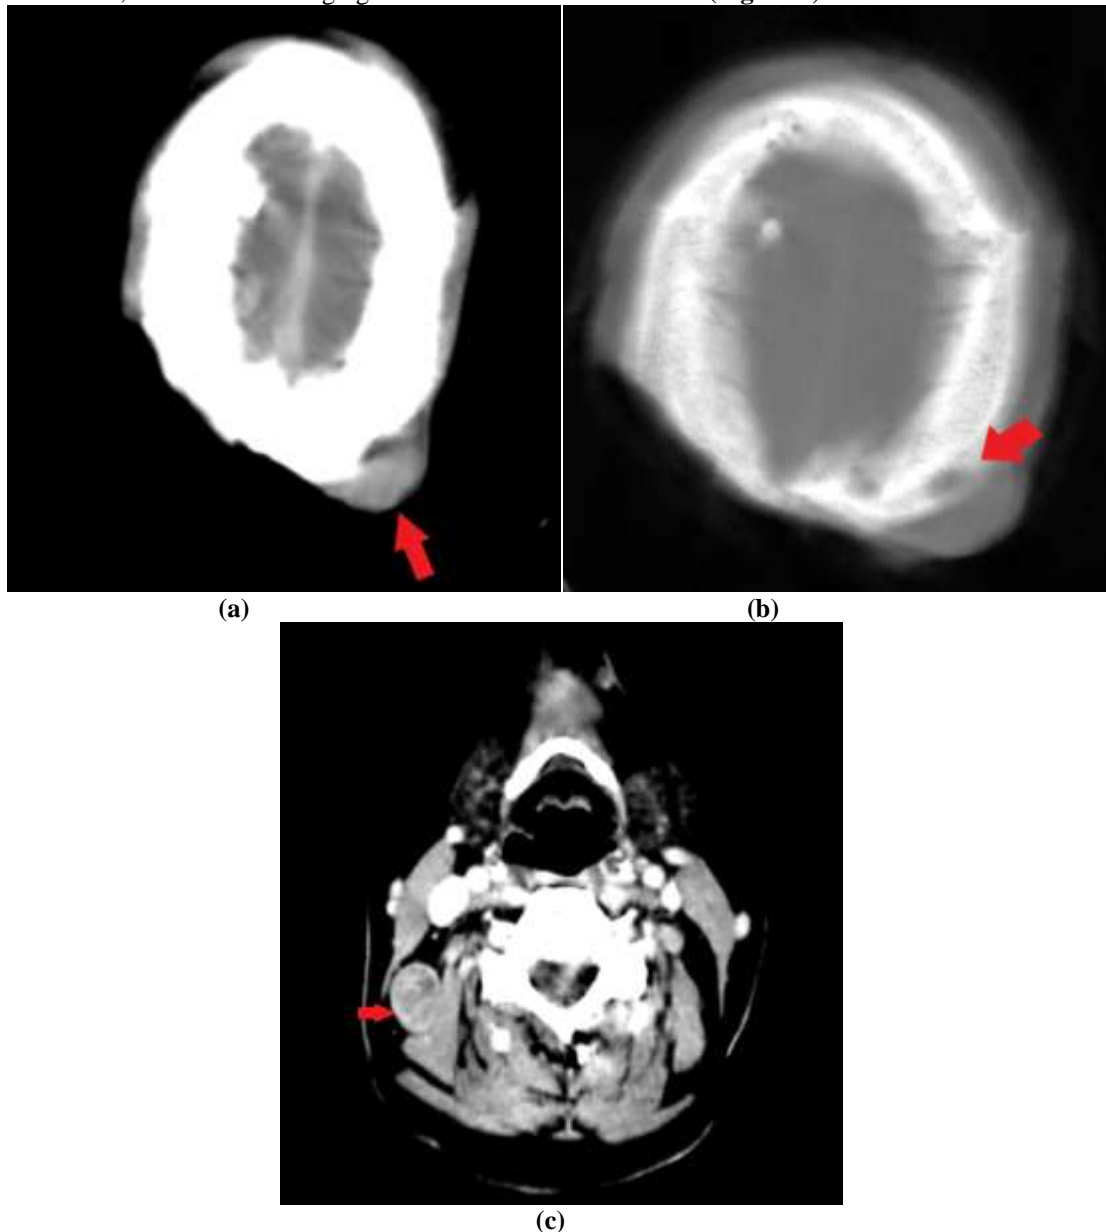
Computed Tomography (CT) scan showing microcystic adnexal carcinoma lesion of the left parietal scalp (a) with underlying bone lysis (b) and right spinal adenopathy (c)
